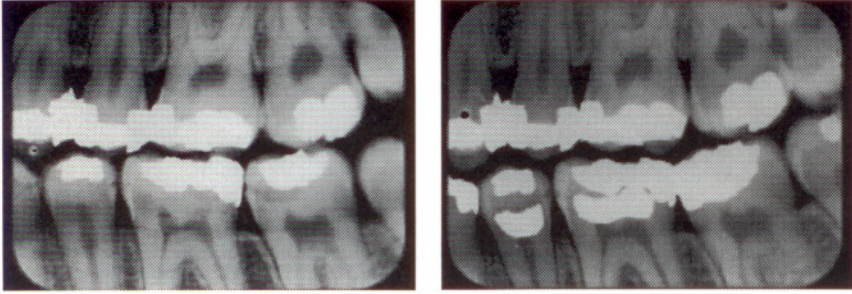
Ante-mortem (a) and post-mortem (b) dental radiographs of a case judged to be easy by both the observers and the authors. One observer made an error on this case in the second evaluation.
